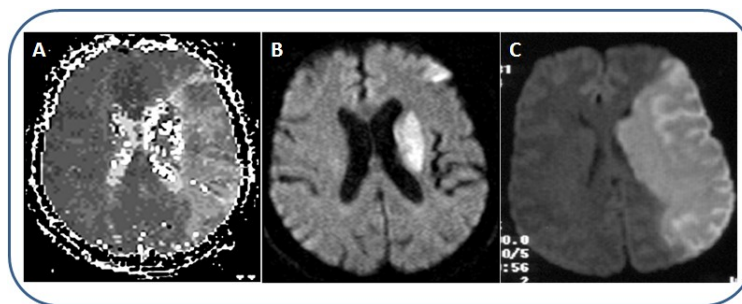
Magnetic resonance imaging (MRI) from an ischemic stroke patient. Perfusion-weighted imaging (PWI) indicating the large area of hypoperfusion at <6 hours after stroke onset (A). Diffusion-weighted imaging (DWI) showing the ischemic core at the same level of PWI at <6 hours after stroke onset (B) and at 48 hours (C).
